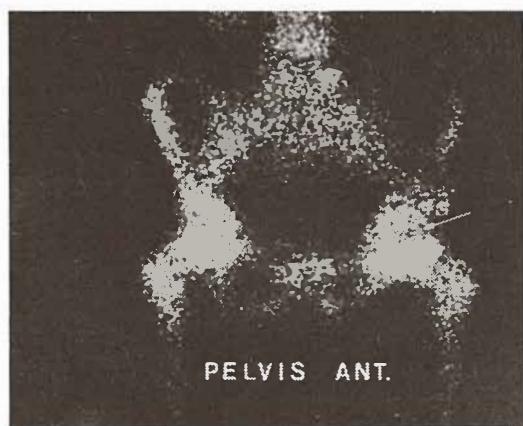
Planar scintigram of the pelvis, photon deficient area (arrow) in the left femoral head
